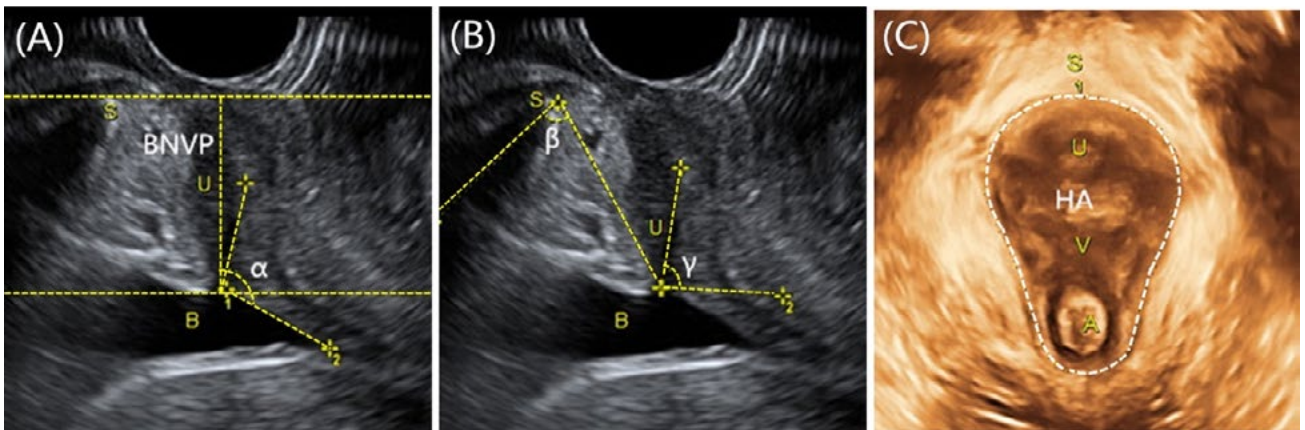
Transperineal ultrasound measurement of pregnant women. (A) the measurement of BNVP and α angle; (B) the measurement of β angle and γ angle; (C) the measurement of HA. B, bladder; S, symphysis pubis; U, urethra; V, vagina; A, anus; BNVP, bladder neck vertical position; HA, hiatal area. (202)
